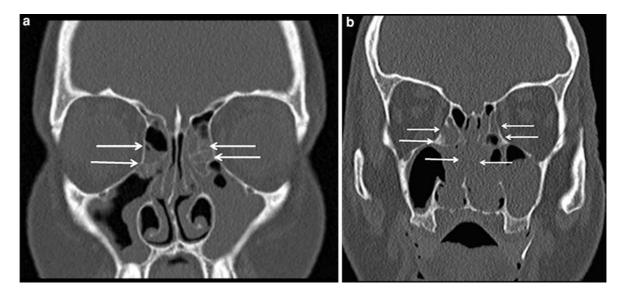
In cases of extensive sinus disease it is difficult to evaluate the integrity of the fine bony (ethmoid) septa (*arrows*), especially at low-dose CT. This can be due to bony erosion, partial volume effect or lack of contrast at low-dose. a axial 2 mm image of a low-dose 6-MDCT with effective dose of 0.12 mSv in a 18-year-old woman at 80 kV and 52 mAs-CTDI
